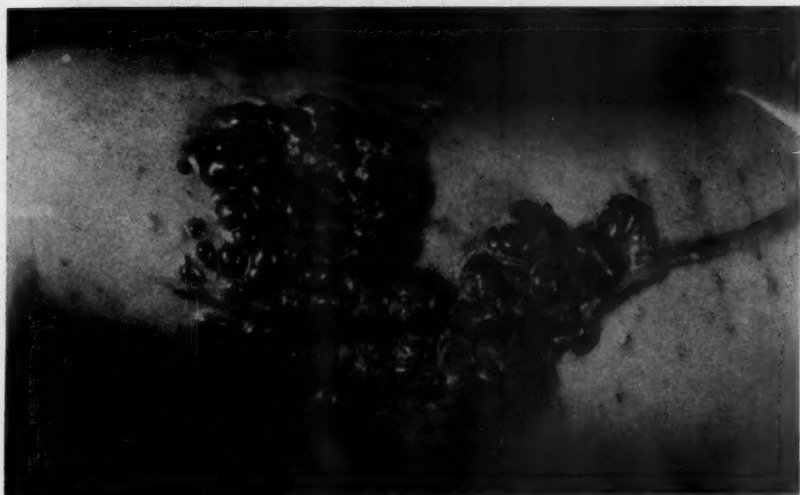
Large melanosarcoma of the thigh recurrent after two excisions, before the onset of deep x-ray therapy and azochloramid dressings. (Case 1.)
